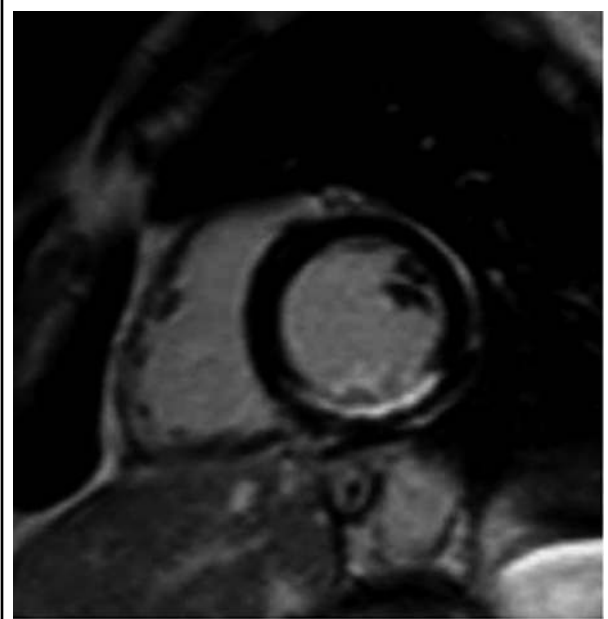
LGE MRI: short-axis view of the left ventricle. Subendocardial infarct tissue exhibits high signal intensity and provides an excellent contrast to non-infarct tissue with low signal intensity.
